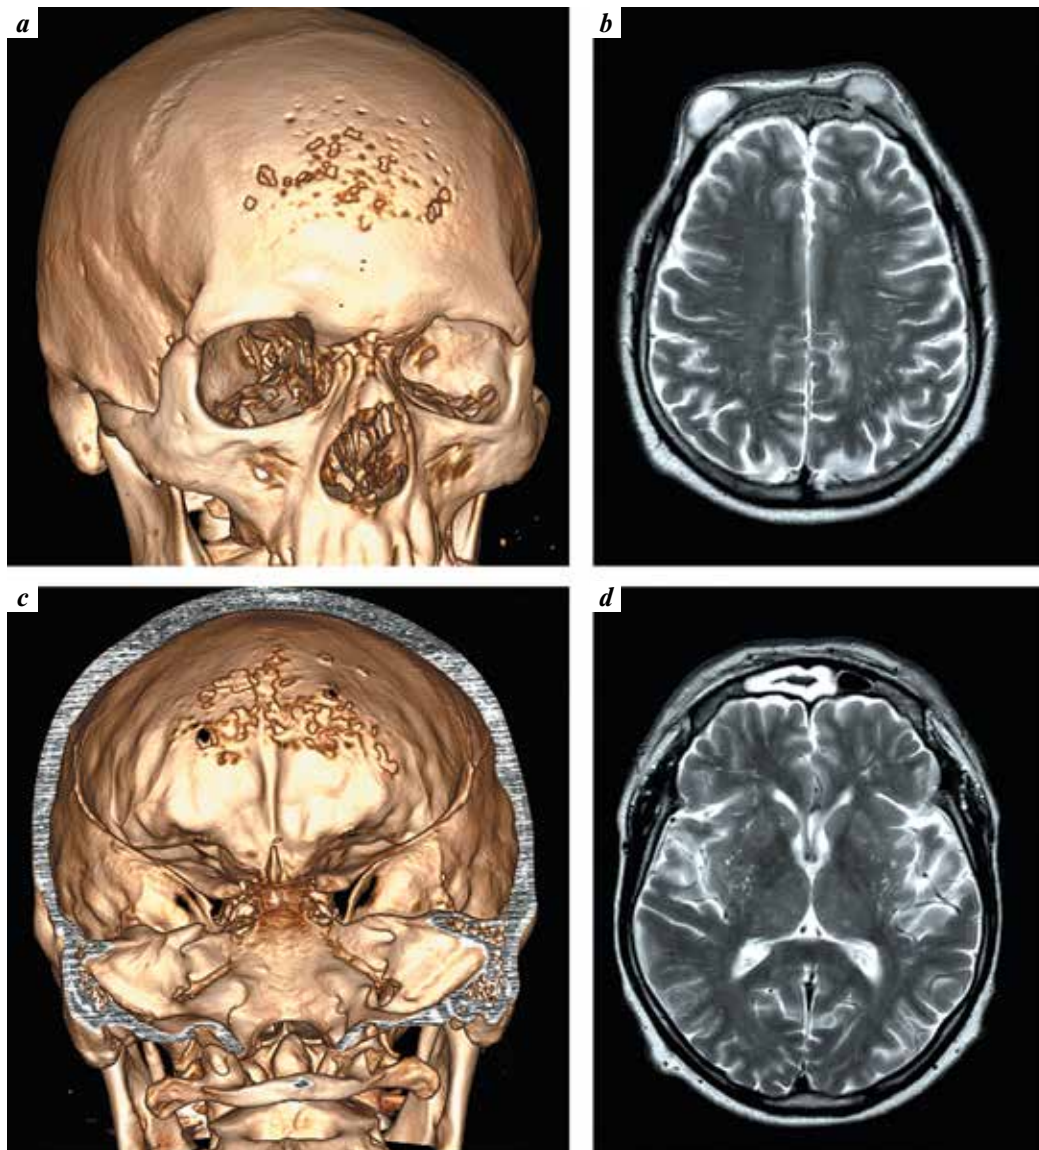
Computed tomography with 3D reconstruction of the skull (a, c) and magnetic resonance imaging (b, d) prior to surgery: a, c — computed tomography images with 3D reconstruction clearly show multiple destruction and perforation lesions in the frontal bone; b, d — T2-weighted images in the axial plane show multiple abscesses of the soft tissues (b) and signs of frontal sinusitis (d)
